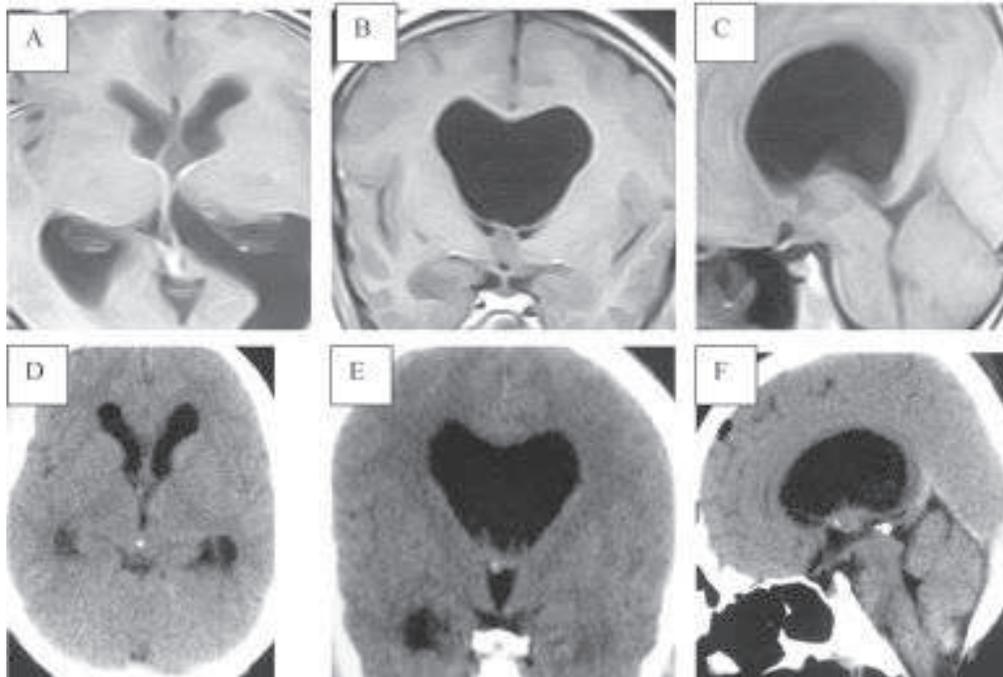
Preoperative MRI and postoperative CT scan of patient. A,B,C revealed axial, coronal and sagittal isointense colloid cyst . Postoperative CT image D, E F revealed very small remnant in the 3rd ventricle, CSF pathway has been reestablished.
